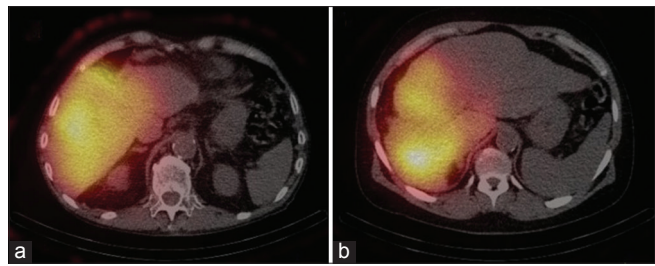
Typical bremsstrahlung SPECT scans after RE with ⁹⁰Y microspheres were acquired with (a) a MEGP collimator and (b) a HEGP collimator. Energy window was set for 100-150 keV
